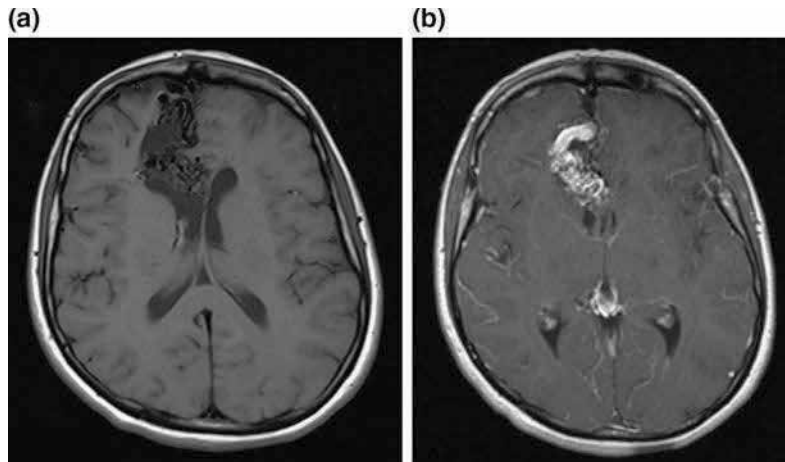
MRI brain axial T1-weighted image (a) shows right mesial frontal arteriovenous malformation. Post-Gd T1-weighted (b) reveals enlarged draining vein.
